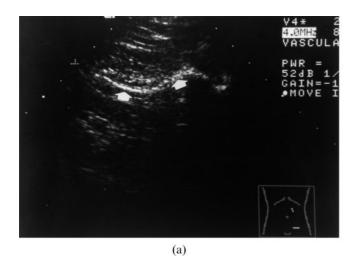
Normal appearance of the polypropylene (PP) and expanded polytetrafluorethylene (e-PTFE) meshes on ultrasound. (a) Transverse ultrasound at the level of the left inguinal canal in a patient with a laparoscopic repair. The PP mesh appears as an echogenic line (thick arrows). (b) Transverse ultrasound at the level of the hypogastrium in a 69-year-old woman with laparoscopic surgery for ventral hernia and an e-PTFE mesh located intraperitoneally. The e-PTFE mesh (long arrow) appears as an echogenic line.
